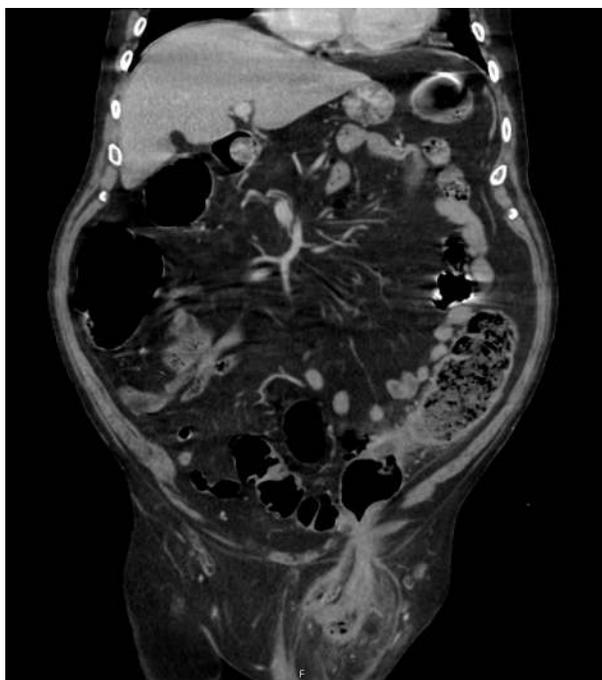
A CT scan showing a closed loop obstruction involving the sigmoid colon caused by an incarcerated inguinal hernia.
